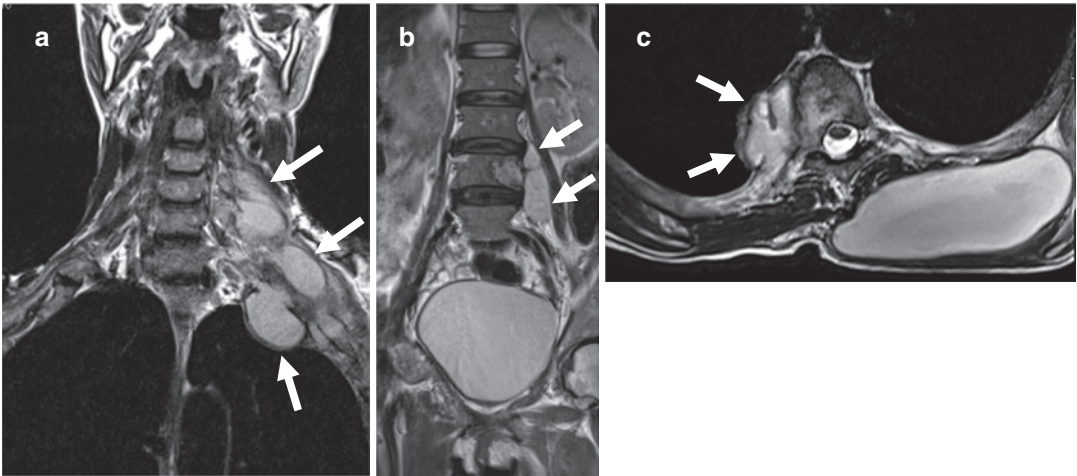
Multifocal spinal tuberculosis. (a and b) Coronal and (c) axial T2-W MR images show multilevel spinal involvement with skip lesions involving the cervical (a), thoracic (c), and lumbar (b) spine (arrows)
